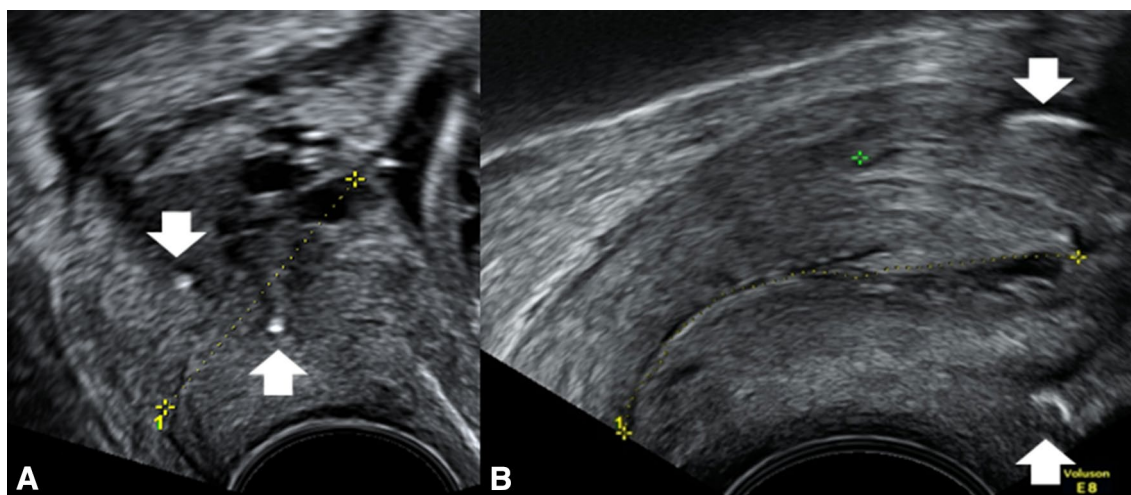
Sonographic assessment of cervical length after vaginal (a) and laparoscopic cerclage (b). The cerclage tapes are marked with white arrows. In a, the yellow line represents the cervical length, while in b, it shows the cervical canal
